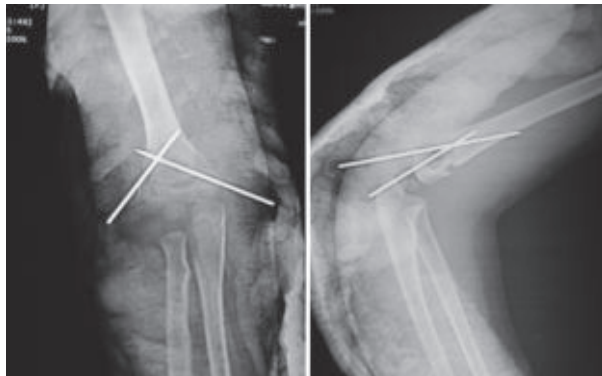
Postoperative x-ray of 8 years old boy
